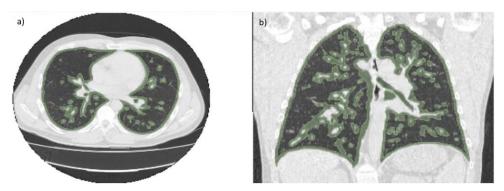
Visualization of the lungs according to spiral computed tomography: a) coronary section, b) frontal section.
